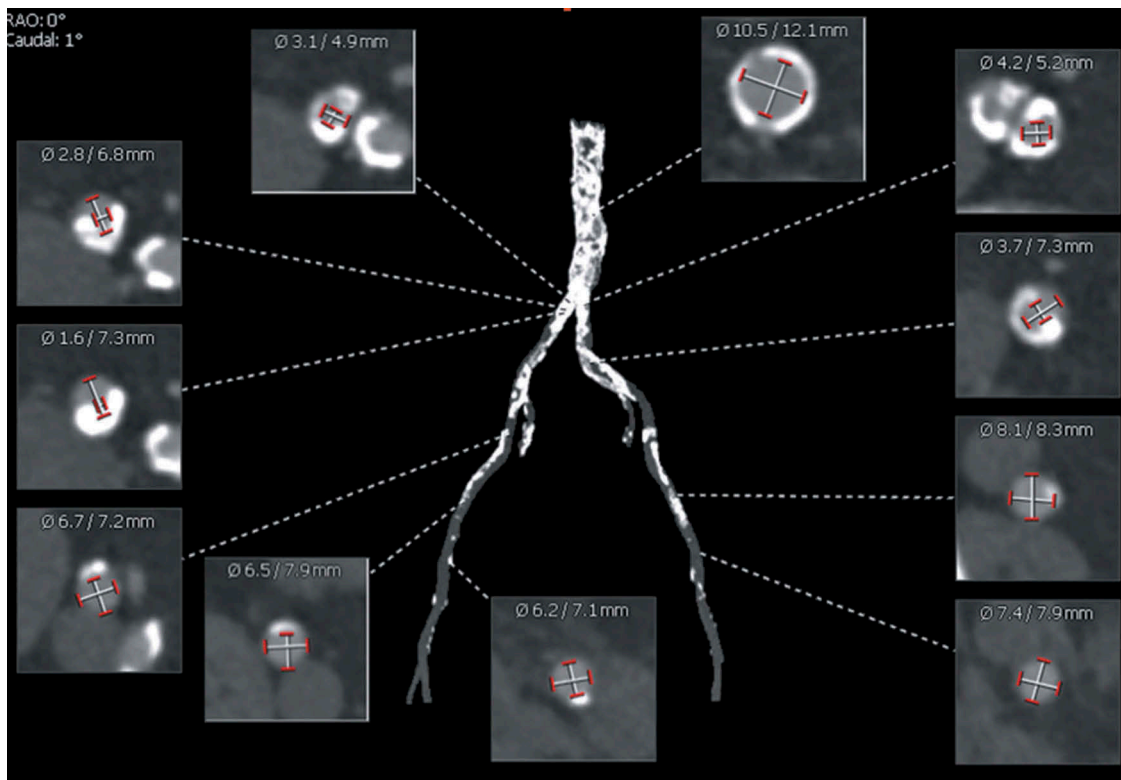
CT angiography measurements—example of diametric iliofemoral measurements.
